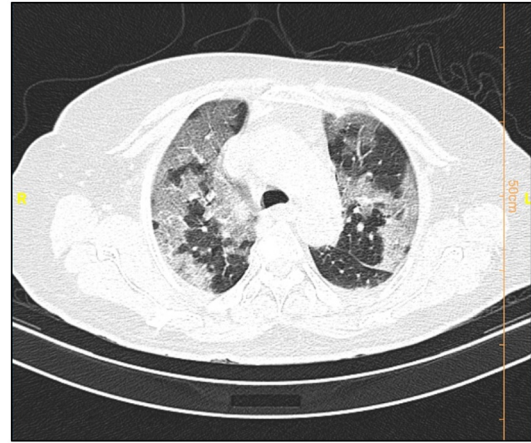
COVID-19 pneumonia: CT scan shows crazy paving pattern.
